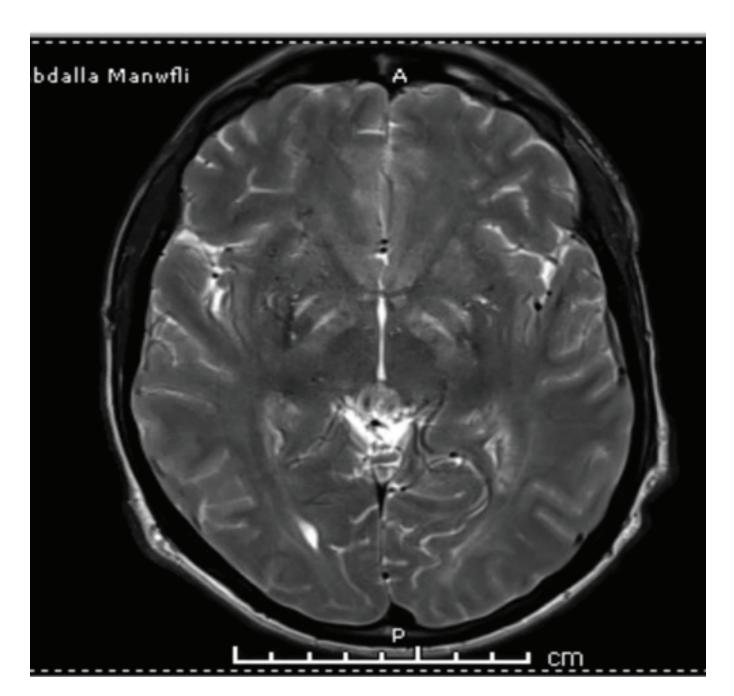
Abnormal T2/FLAIR signal intensity involving bilateral cerebral deep white matter extending throughout basal ganglia and internal capsules to the brainstem and upper cervical cord up to C4-5 level.
